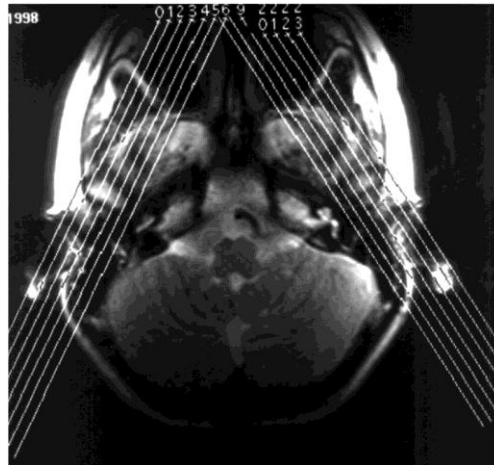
Angulated parasagittal slices, thickness 3mm, for MR imaging
